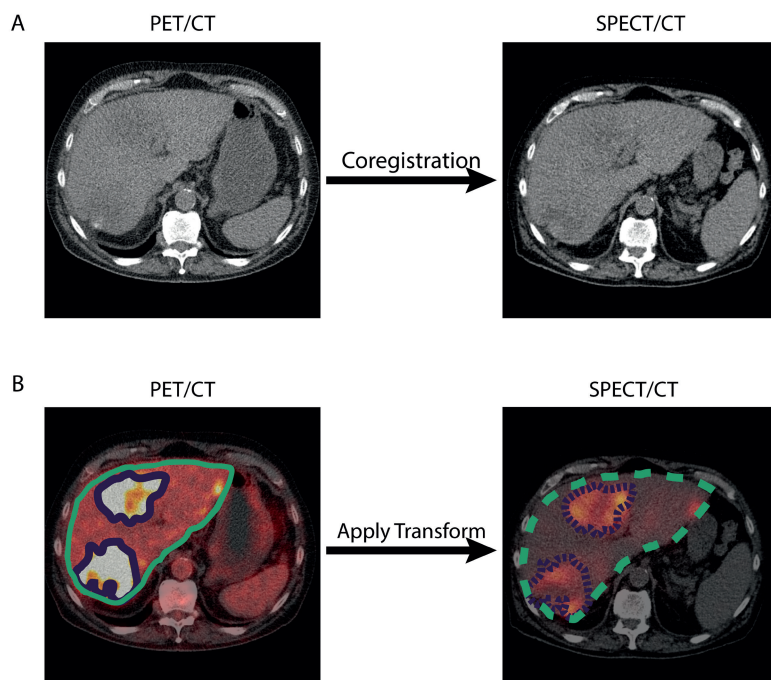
Example of tumor delineation and absorbed-dose estimation. Using the liver contour, the low-dose CT of the PET was matched to the low-dose CT of the SPECT (A). The tumors were automatically defined using a threshold. Liver- and tumor contours were transferred from the PET/CT to the SPECT/CT and absorbed doses were calculated (B).
